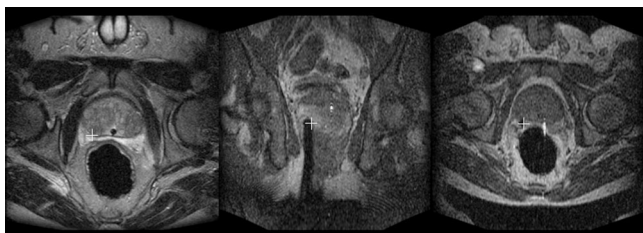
MR images from a clinical study (63 years old; PSA = 27.9 ng/dL; prostate volume = 116.0 cc) showing the deflection of needle in a targeted prostate biopsy. (left) T2-w image with cross mark indicating a target, (middle) coronal coherent gradient echo image with needle artifact and original tumor target location (cross mark), and (right) axial coherent gradient echo image with needle artifact and target location (cross mark). Note that the needle deflects toward the right side of the patient.
